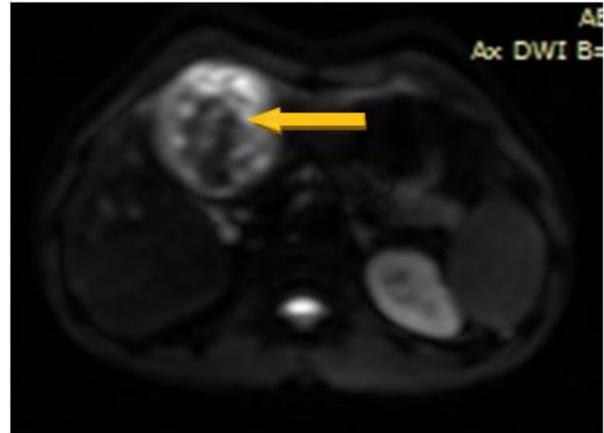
DWI image showing diffusion restriction (arrow) within the lesion (case 1).
